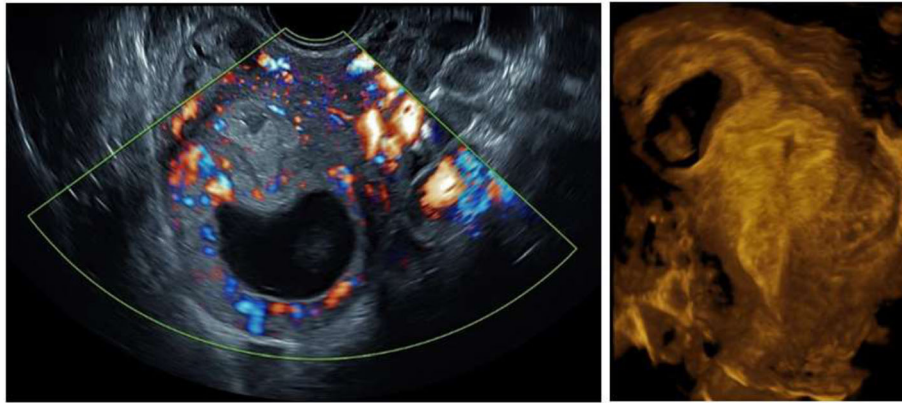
Case 2: interstitial pregnancy on ultrasound: Left: 2D image showing high flow in the thin surrounding myometrium. Right: 3D rendered image showing the interstitial localization
